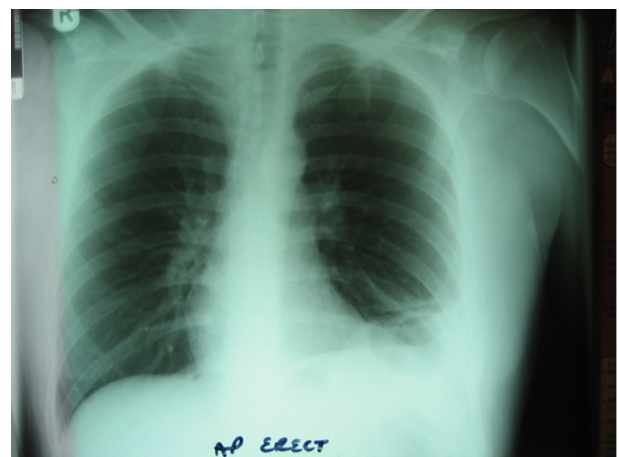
Post-Operative Chest X-Ray Showing Resolution of Diaphragmatic Hernia
